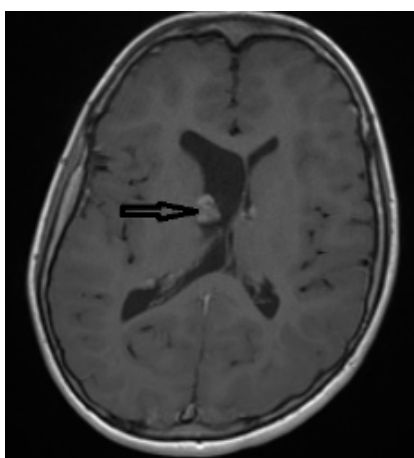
Axial FLAIR MRI shows subependymal nodule along the lateral wall of the lateral ventricle (black arrow).
